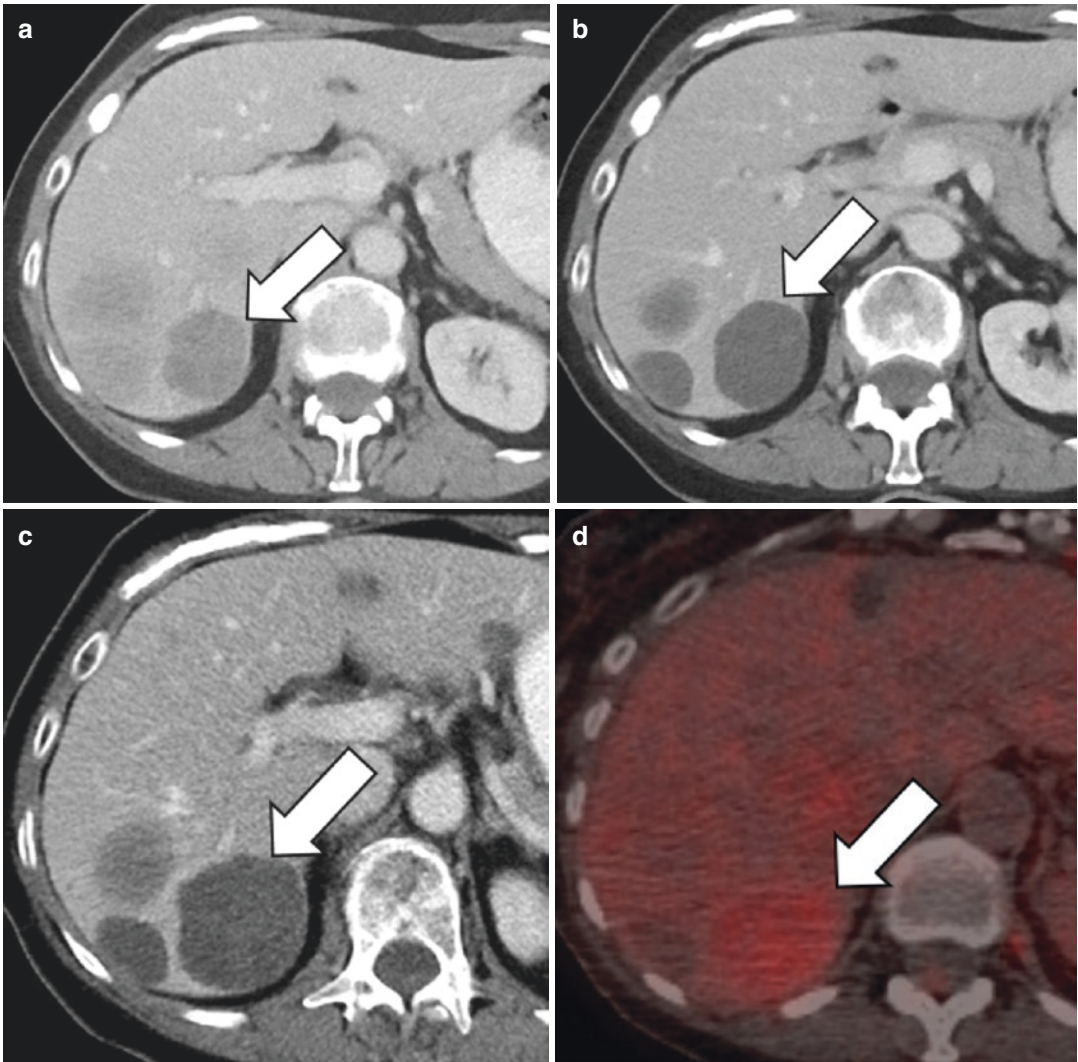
68-year-old woman with GIST metastatic to the liver treated with imatinib. (a) Baseline contrast-enhanced CT of the abdomen demonstrates multiple heterogeneously enhancing liver metastases (arrow). (b) Follow-up CT scan 3 months after treatment with imatinib demonstrates typical response to therapy, with homogeneously decreased density and enhancement of the liver metastases. There is apparent increase in size of the index liver
